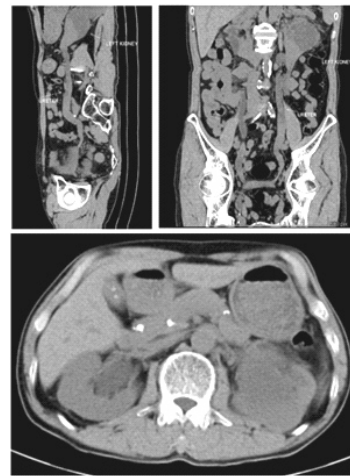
CT Scan in December 2021 showed an increase in multifocal tumor mass in the left ureter.
